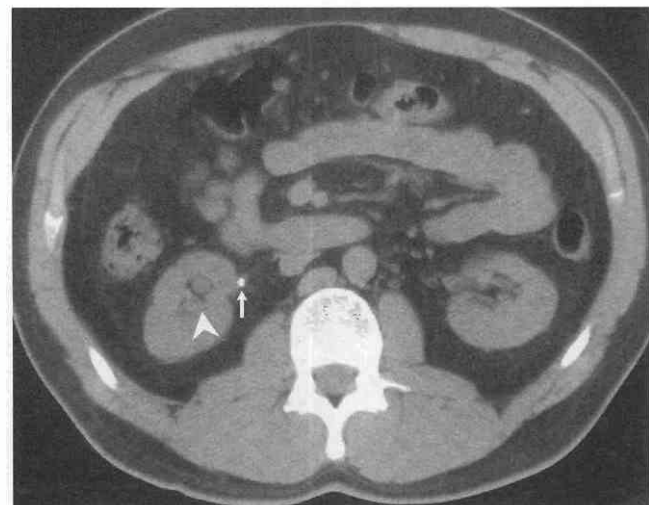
Non-contrast renal CT protocol. Axial image demonstrates a 3- to 4-mm calculus (arrow) in the right ureteropelvic junction with mild hydronephrosis (arrowhead).
